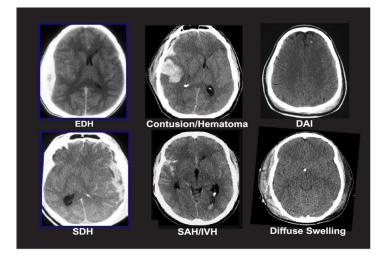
CT image – Head injury
